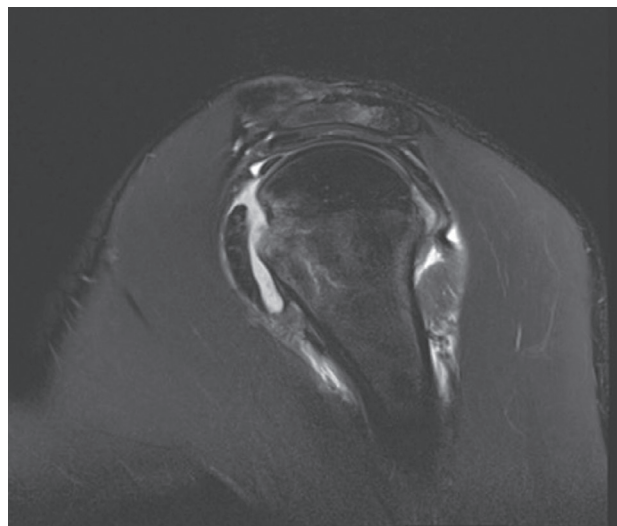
Coronal T2-weighted fat suppressed images of the left shoulder. There is a fracture of the medial aspect of the left humerus with associated high T2 marrow signal, in keeping with marrow oedema. This is an example of a reverse Hill–Sachs lesion.
